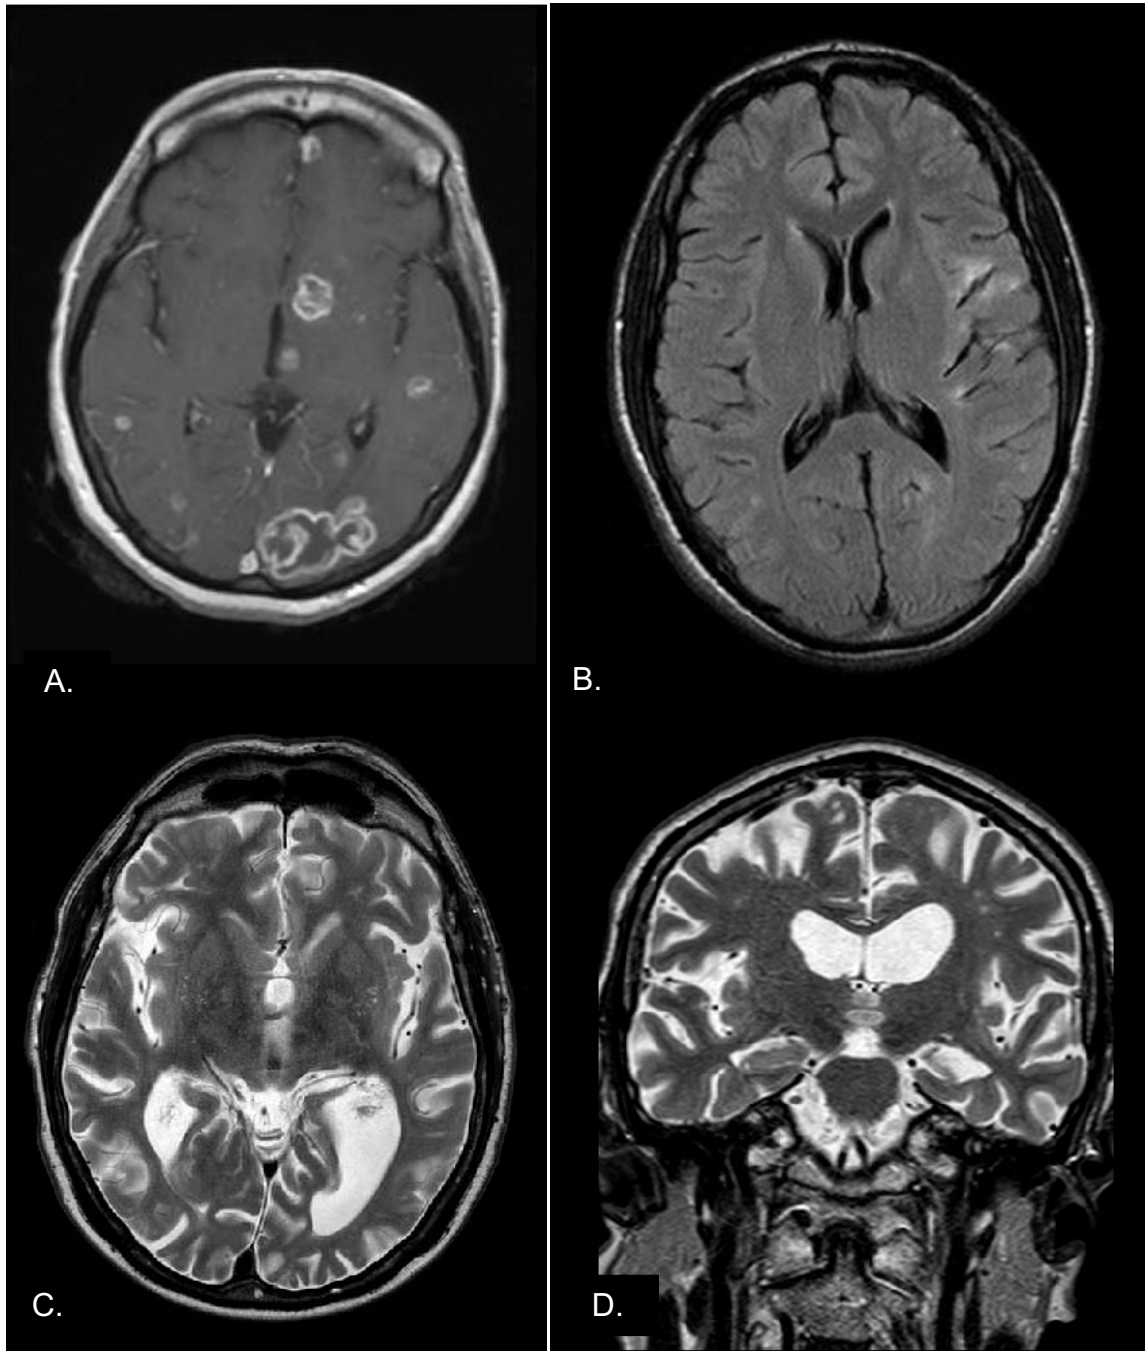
MRI images: A. Case I - Axial T1 MRI image enhanced with contrast showing multiple ring enhancing lesions in a patient presenting with status epilepticus in the context of HIV and Cerebral Toxoplasmosis; B. Case II - Axial T2 FLAIR image showing multiple high signal intensity foci in keeping with gliosis in the site of a previous infection in a patient treated for seizures on background of HIV and ongoing treatment for TB meningitis; C. and D. Case III - Axial and coronal T2 images showing focal atrophy of the left temporal lobe and hippocampus on background global atrophy in a patient with refractory epilepsy in the context of HIV and PML.
